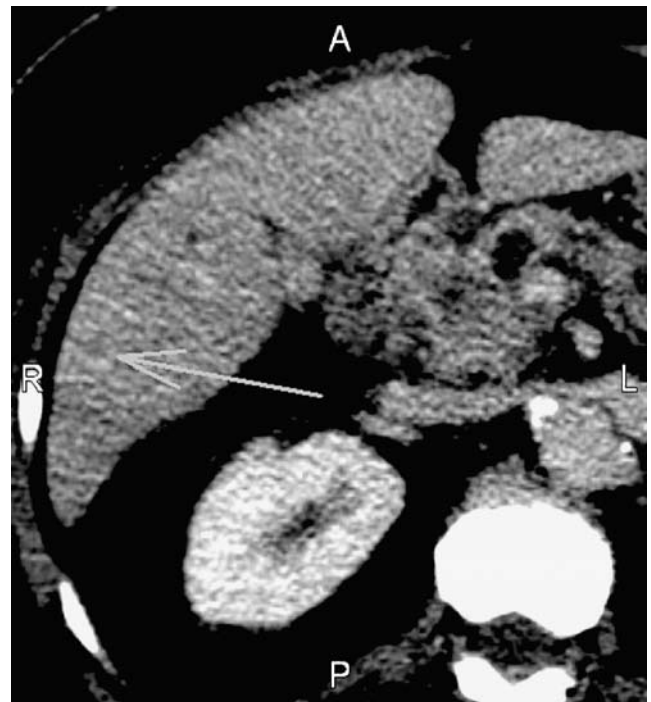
Abdominal CT scan with indeterminate but suspicious lesion in the liver (arrow).
